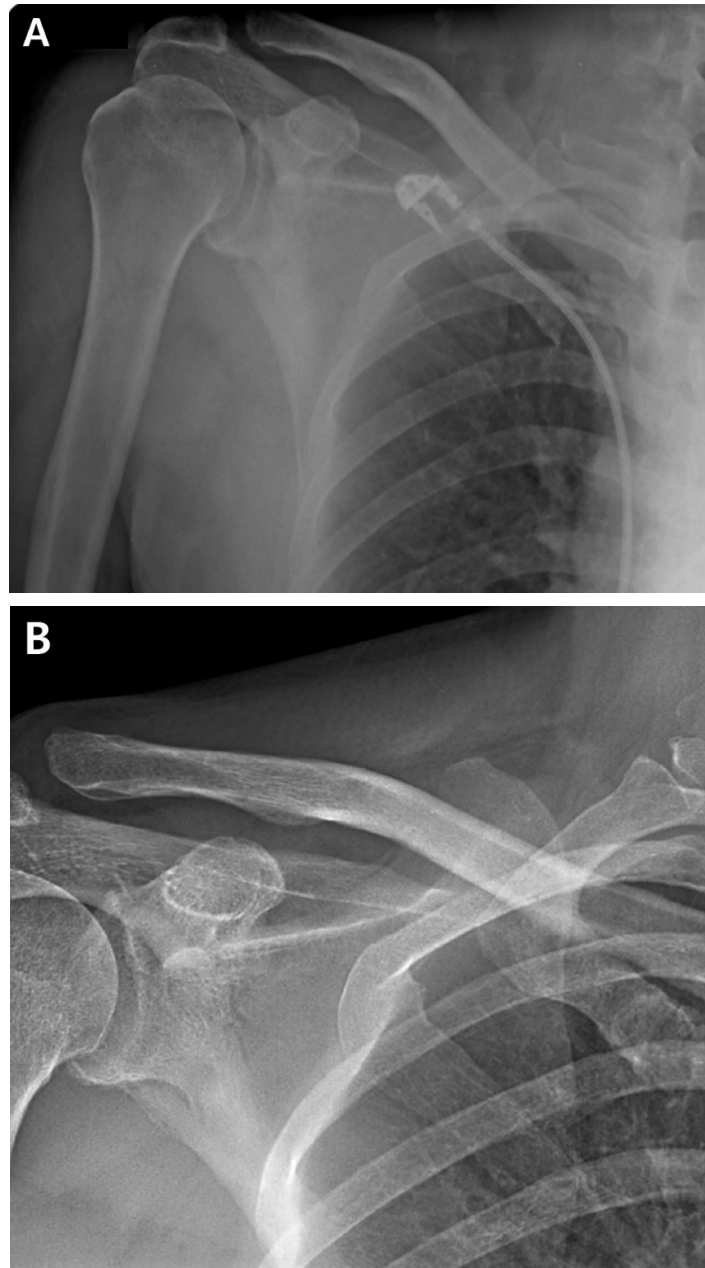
(A). Immediate postoperative anteroposterior radiograph. (B). Anteroposterior radiograph of the shoulder 6 months post-operation showed no significant change in the radiographic findings of the glenohumeral joint.
